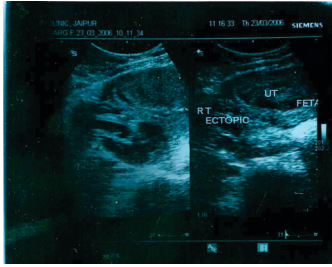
Transabdominal ultrasonography on 23-03-06 revealed intrauterine and extrauterine live pregnancy of 7-8 weeks.
